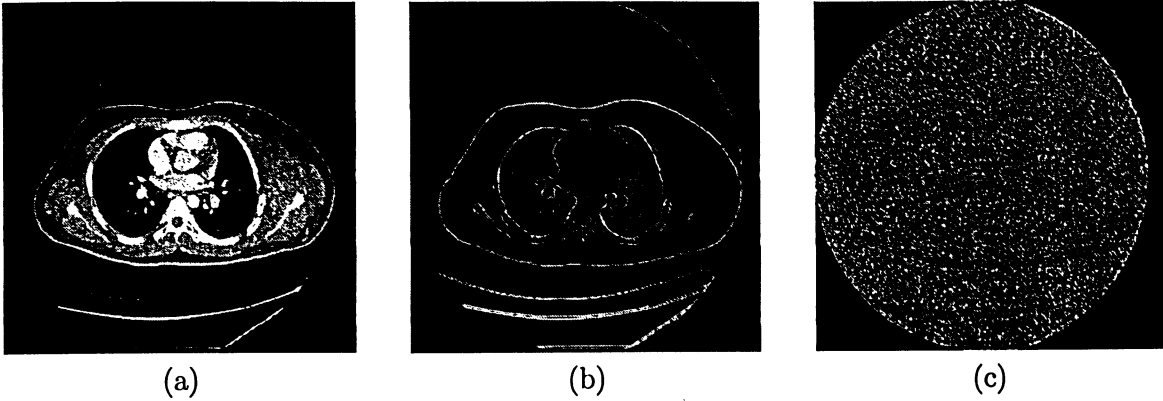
(a) Original pulmonary CT image. (b) The gradient image of figure (a) using Sobel masking. (c) Result with oversegmentation obtained using standard watershed transform on the gradient image.
